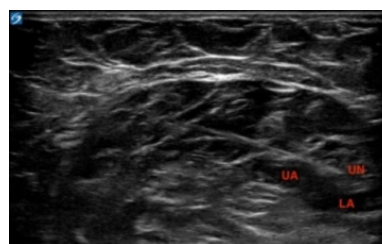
This shows the ulnar nerve (UN) separated from the ulnar artery (UA), which runs closer to the ulnar artery as you scan distally along the arm using a high-frequency linear ultrasound probe in a transverse position (Sonosite, Bothell, Washington, USA). However, in this image, 2 cm distal to the antecubital fossa, the UN has separated from the UA, allowing for an easier needle approach. The 21-gauge echogenic blunt-tipped needle (BBraun, Bethlehem, Pennsylvania, USA) was advanced in-plane from lateral to medial.
